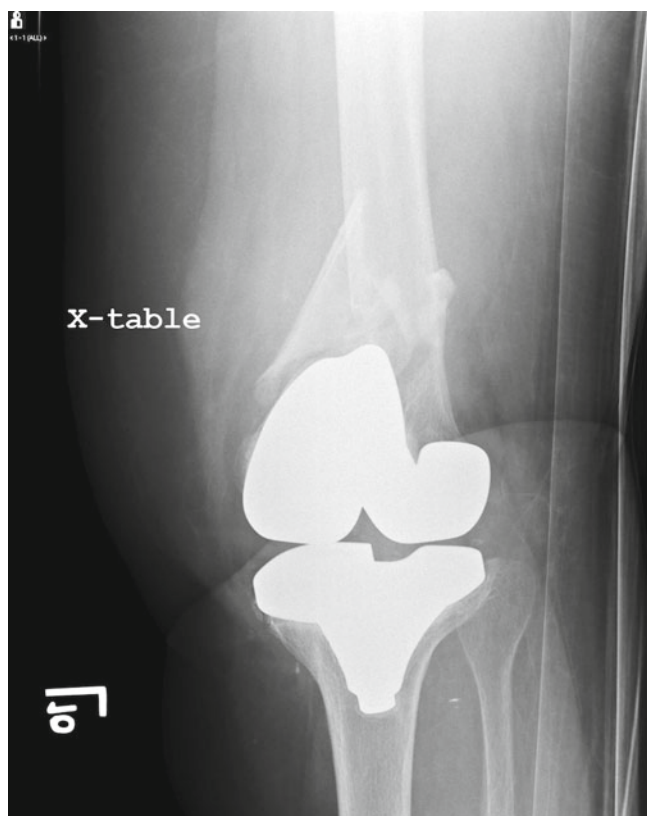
AP knee X-ray of a periprosthetic femur fracture above a knee replacement
